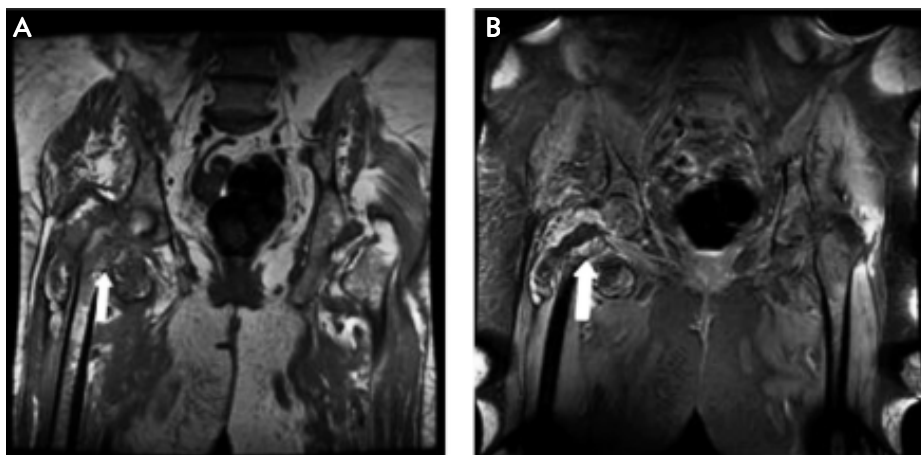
MRI shows basicervical proximal fracture of the right femur with varus angulation of the epiphysis, edema and tumoral infiltration (arrow).
